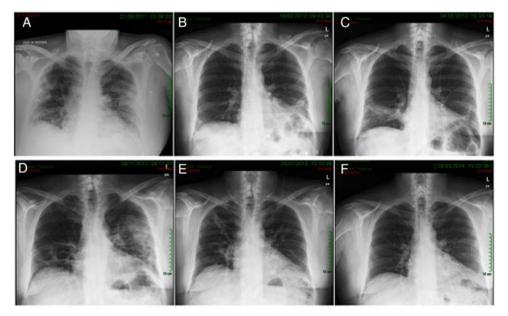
Evolution of chest X-rays: (A) at diagnosis, (B) improvement after receiving prednisone 30 mg/day, (C) first relapse, with a daily dose of 12.5 mg/day of prednisone, (D) after 6 months of treatment with methotrexate (25 mg/week) and prednisone 25 mg/day, (E) after two rituximab infusions, methotrexate and prednisone 25 mg/day and (F) after two infusions of tocilizumab plus methotrexate, prednisone can be tapered to 5 mg/day without any relapse of organising pneumonia or arthritis.
